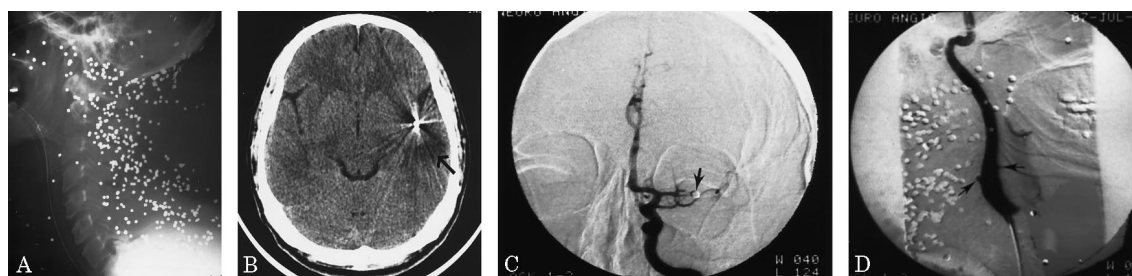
(A) Lateral X-ray of the neck shows numerous pellets. (B) Unenhanced transaxial CT shows an intracranial pellet without evidence of skull or parenchymal lesions to account for pellet entry pathway. The arrow points to the area of infarction, which extends superiorly. (C) Anteroposterior view of the cerebral angiogram shows a pellet (arrow) in the left middle cerebral artery. (D) Oblique lateral projection of the angiogram shows two small pseudoaneurysms (arrows) in proximal left internal carotid artery, indicative of pellet entry site.
